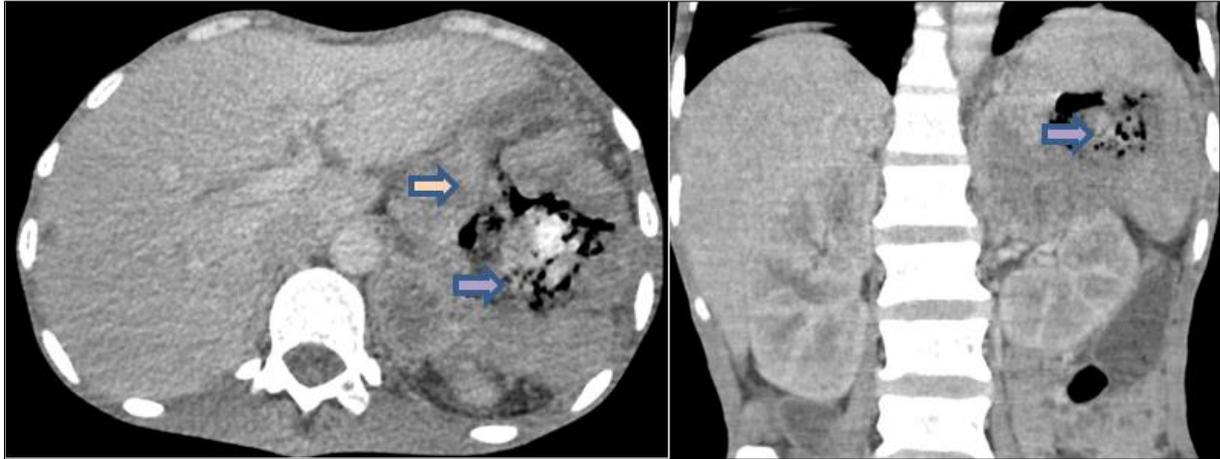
Abdominal CT with contrast
